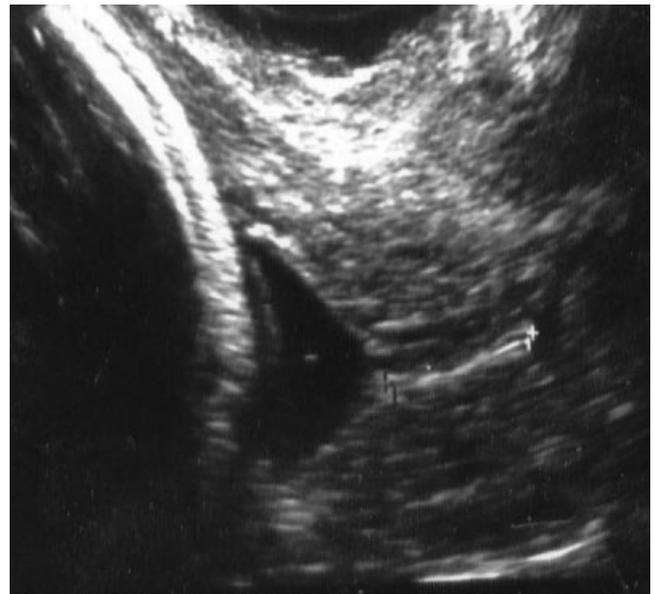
Measurement of cervical length by transvaginal sonography.
